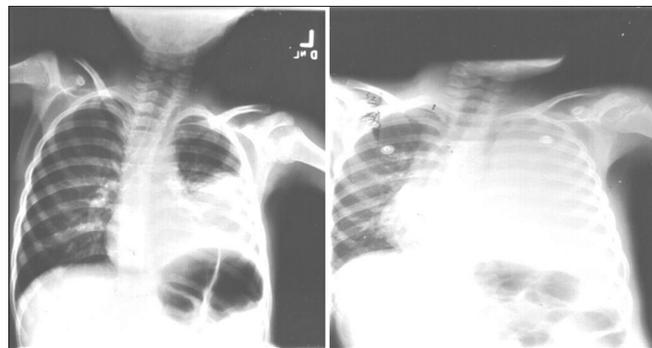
(left) First x-ray of Case number 1; (right) One week later.
